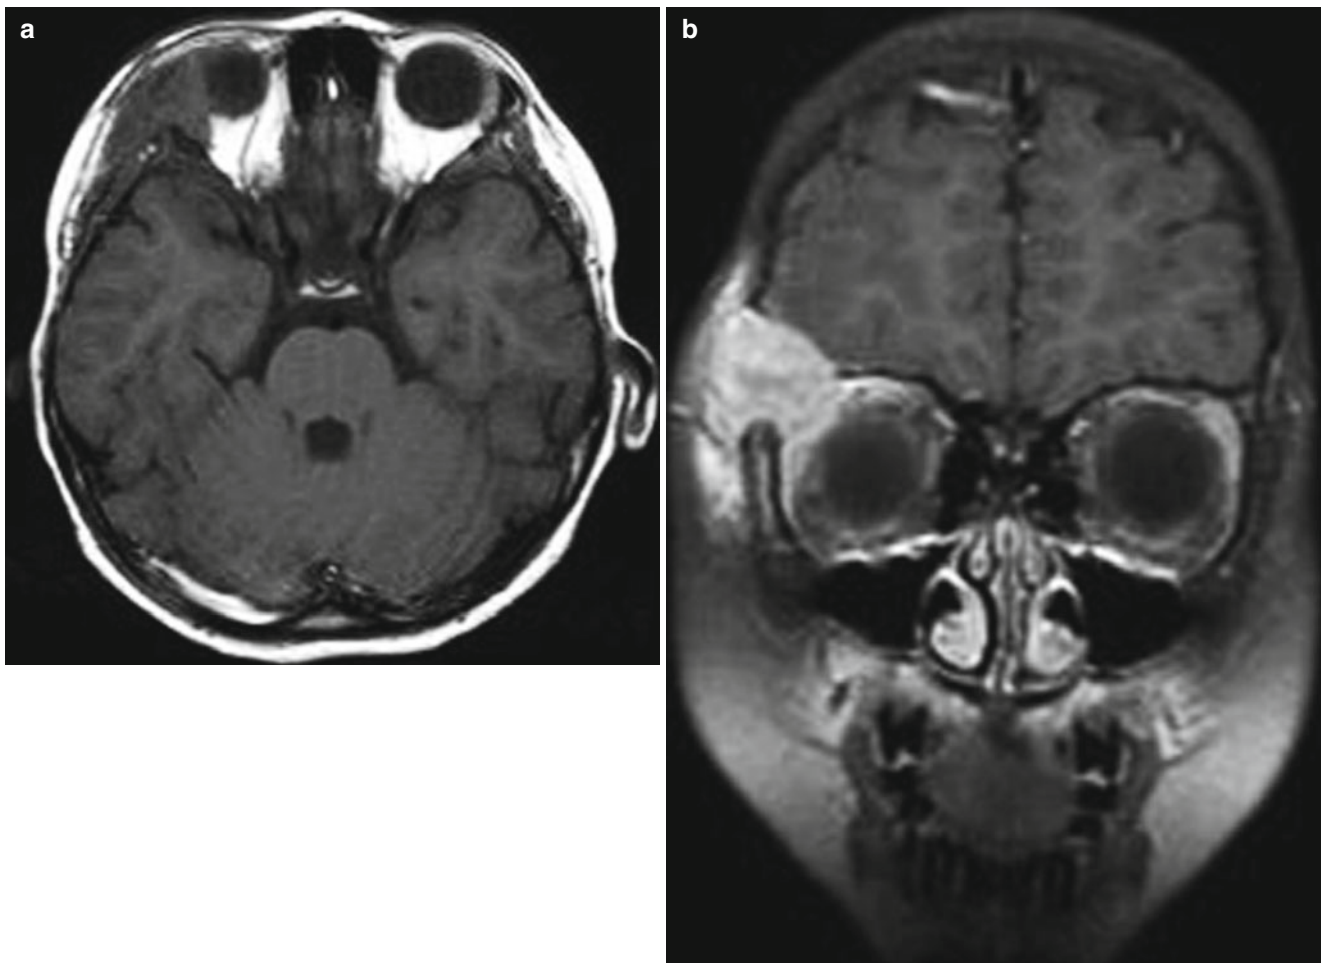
Orbital LCH in an 8-year-old girl. (a) Axial T1-weighted MR image shows a soft tissue mass of iso-signal intensity relative to normal brain tissue in the superolateral aspect of the right orbit.
